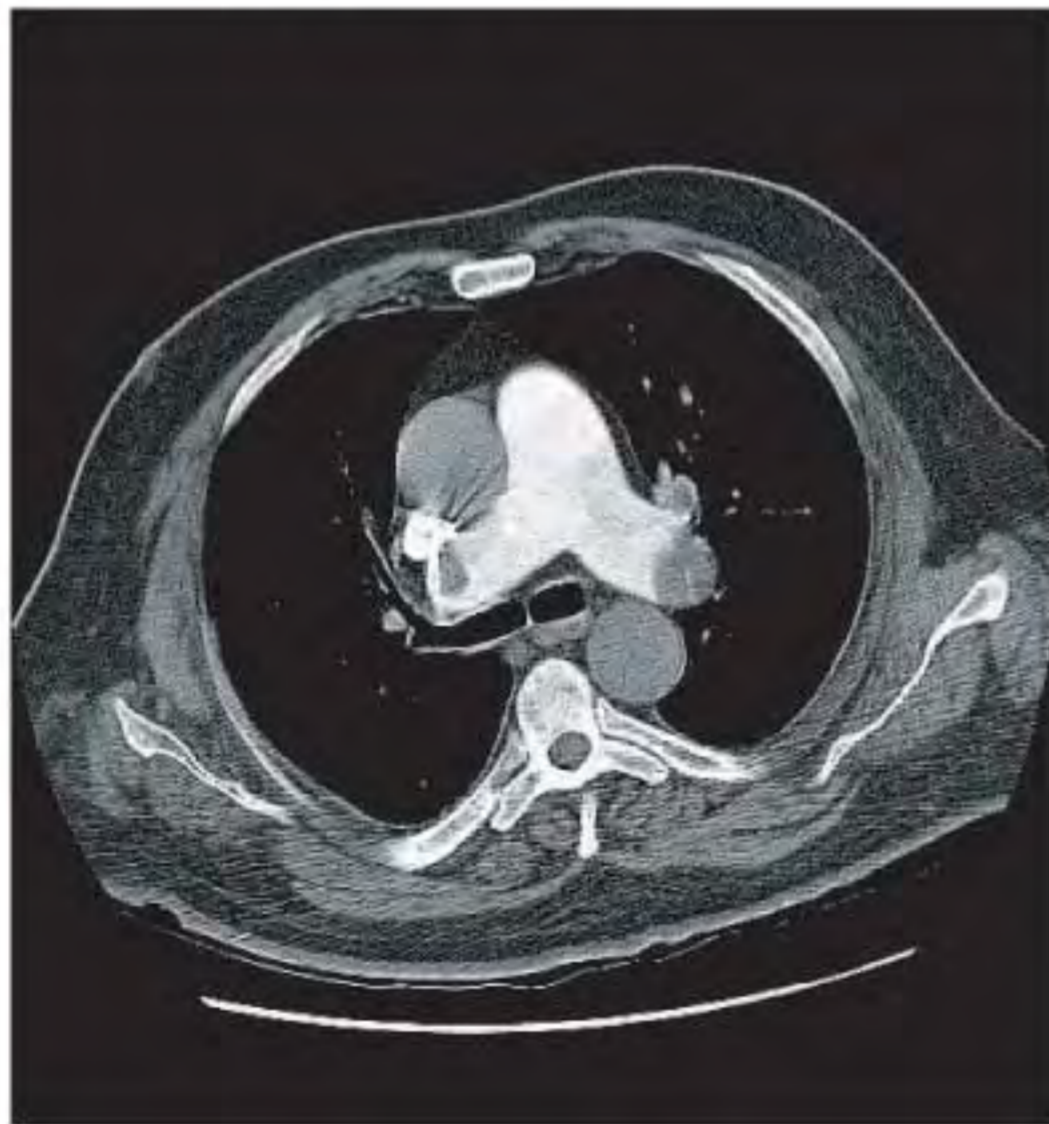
CT angiogram of Chest showing embolus (black arrows) in both right and left main Pulmonary artery branches, on arrival in Accident & Emergency department.
